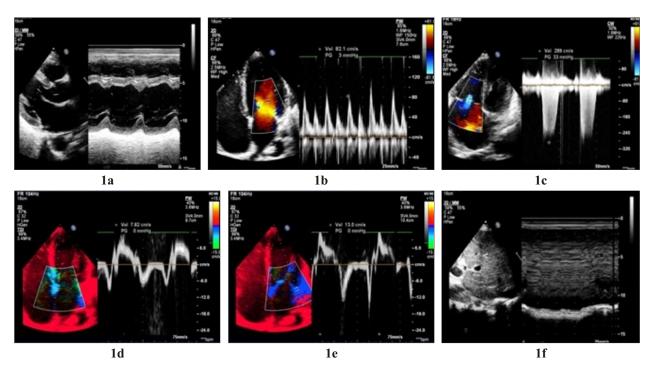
2d echocardiography ap presentation showing ventricular septal shift i.e. septal bounce (1a), respiratory variation in ventricular filling i.e> 25% respiratory variations in mitral valve inflow pattern (1b), mild pulmonary hypertension (1c), normal tissue doppler imaging (1d, 1e), dilated & congested inferior venacava (1f).
